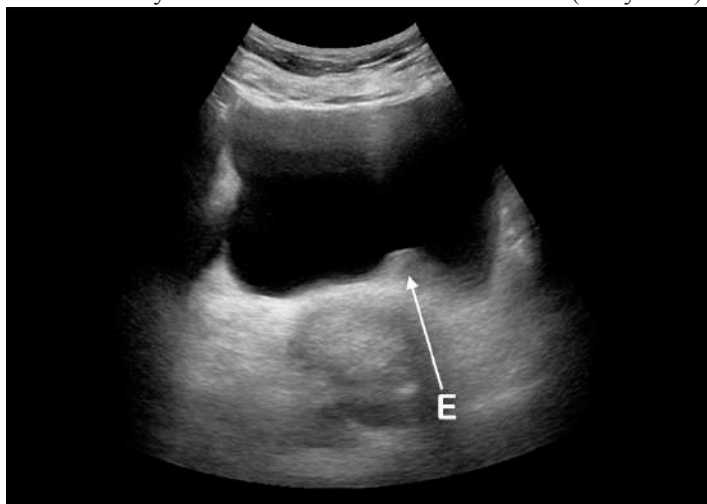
Emergency department ultrasound (EDUS). Inward protrusion from edema (E) without stone visualization at the left posterior bladder wall.
